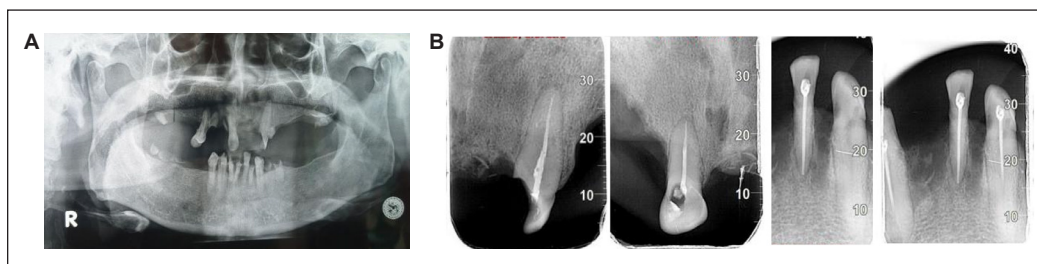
Radiographic examination: (A) panoramic radiograph; and (B) periapical radiograph showing teeth 11, 23, 31, 33, 43, and 44
